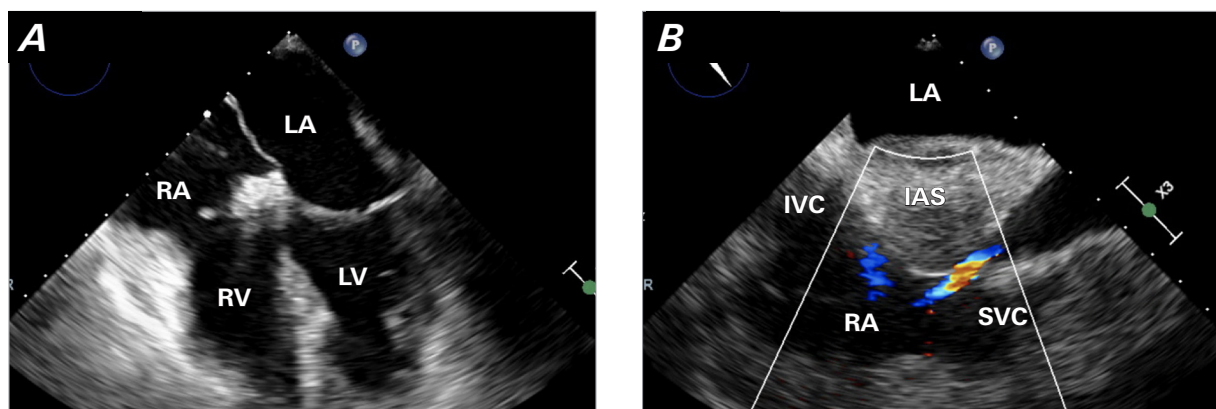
Preoperative transthoracic echocardiogram. A) The 4-chamber view of the heart shows the tumor on the IAS projecting toward the right atrium. B) The bicaval view of the heart shows the tumor on the IAS creating a stenosis on the SVC/right atrial junction.
